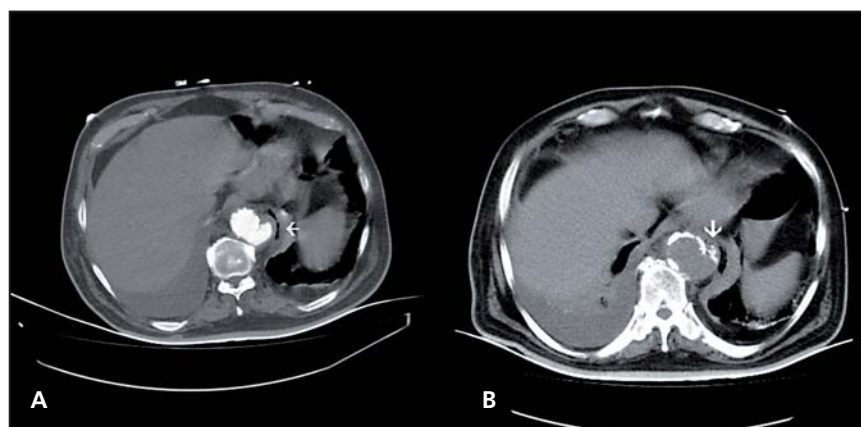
Computed tomography angiography of the thoracic aorta demonstrating saccular aneurysm with associated periaortic inflammation and air collection (arrow) suggestive of aortic abscess (A). On non-contrast CT image, the aneurysm is surrounded by atherosclerotic calcific plaque and the plaque (arrow) replace to periaortic tissue suggestive of rupture (B). CT – computed tomography.
